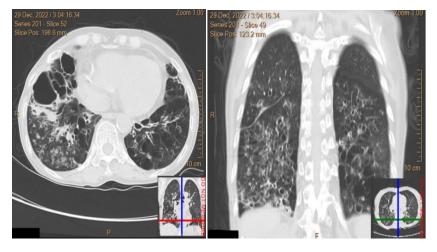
HRCT Thorax Multiple cystic features appeared in both lungs, especially on the pulmonary posterobasal aspect. The size of the lesions varies, most of the walls are thin and some have thick walls and a honeycomb (+) appearance is seen. There is an air fluid level (+) on the cystic picture, especially in cysts with rather thick walls on the posterobasal aspect of the pulmo. There was fibrosis and patchy infiltrates with ground glass opacity infiltrates in the right pulmo posterobasal and left perihilar infiltrates.
